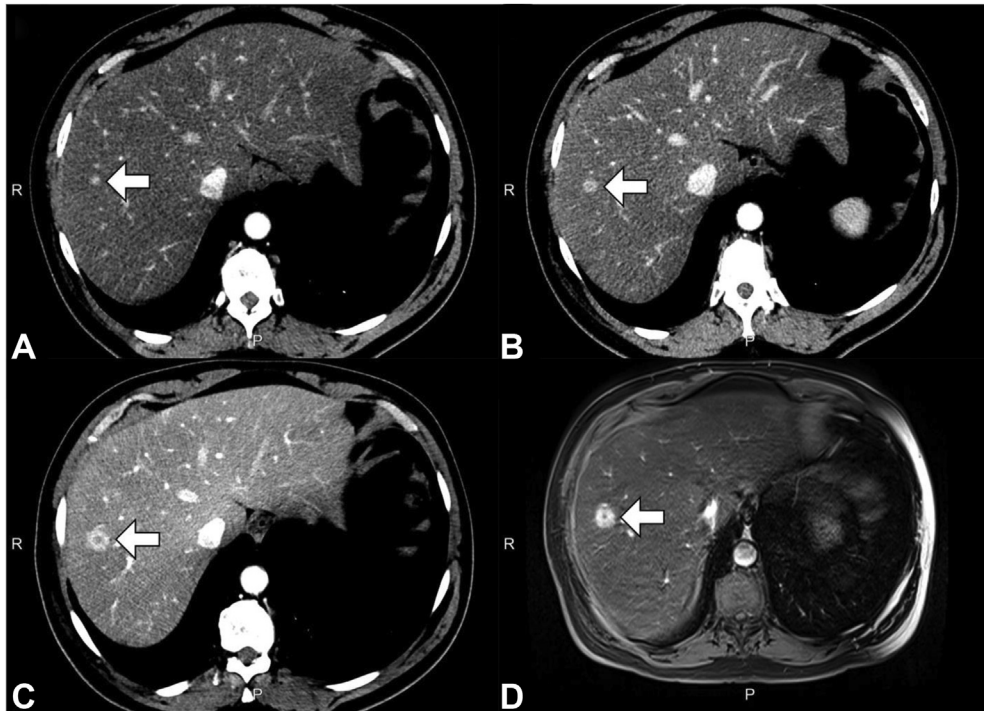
Radiographic imaging for patient A. CT of the liver during arterial phase of contrast administration reveals (A) a small lesion in hepatic segment VIII that avidly enhances and progressively enlarges on subsequent scans (B) 11 months and (C) 22 months after. (D) Corresponding hepatic MRI with intravenous contrast reveals the same enhancing liver lesion without additional tumors. CT, computed tomography; MRI, magnetic resonance imaging.
